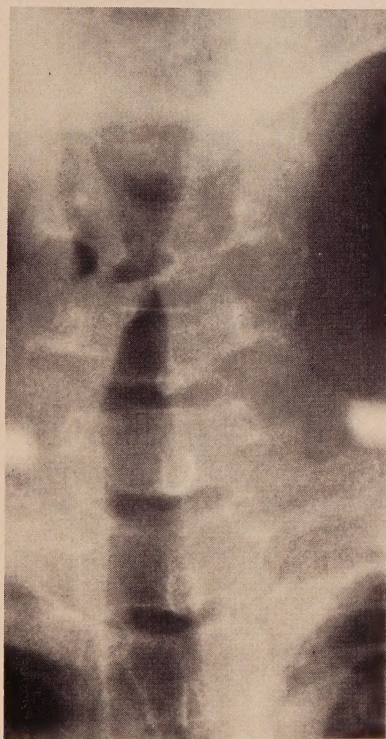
Frontal Radiograph of the Larynx, Showing Abduction and Atrophy of the Left Vocal Cord with Deformity of the Laryngeal Ventricle Consistent with Vocal-Cord Paralysis.
